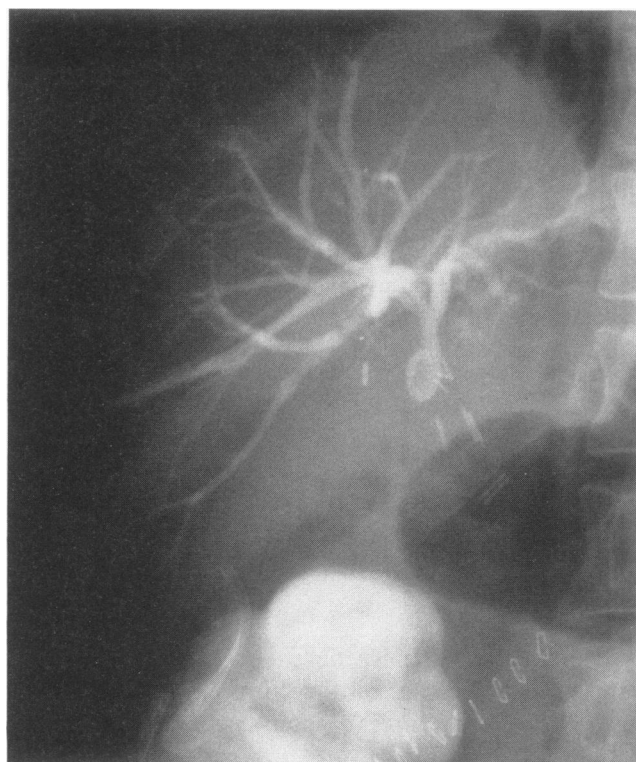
(A, top left) Percutaneous transhepatic cholangiography showing complete common hepatic duct obstruction. (B, right) Preoperative percutaneous transhepatic catheter placed via the right hepatic ductal system into the obstructed common hepatic duct. (C, bottom left) Postoperative percutaneous cholangiogram showing patency of the hepaticojejunostomy without biliary leakage. The coronary O ring can be seen at the bottom of the radiograph.
